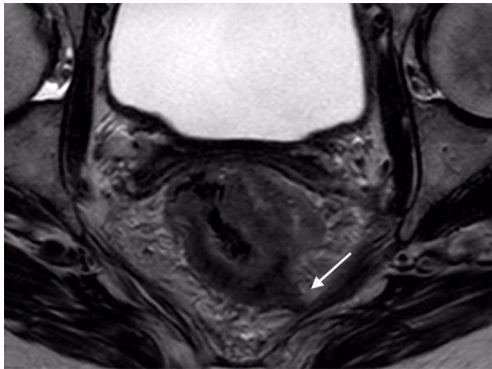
Rectal MRI shows tumour extension to the left sacrospinous ligament. Neoadjuvant chemoradiotherapy and beyond TME surgery is indicated.
